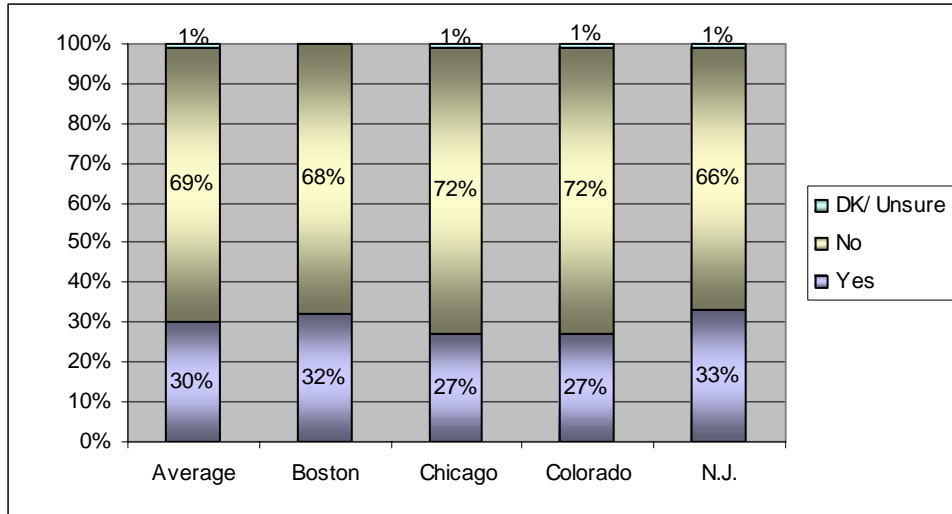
DO CONSUMERS BELIEVE SEAFOOD IS BEING INSPECTED FOR QUALITY AND SAFETY?
